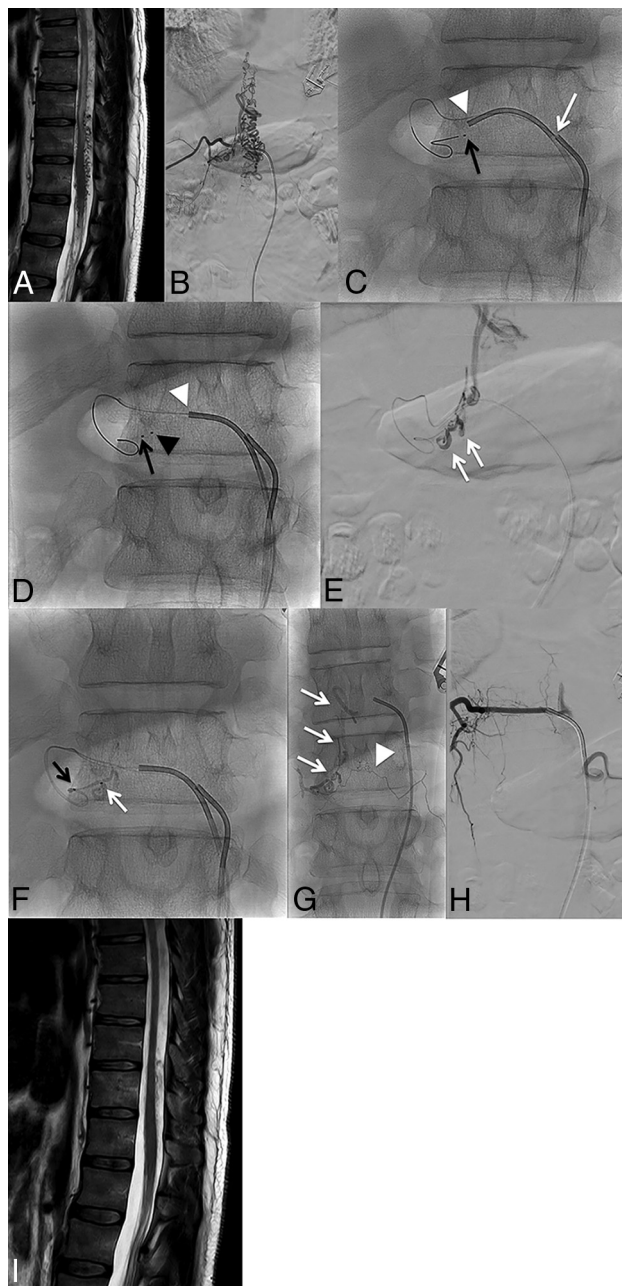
Patient in his or her 40's presenting with lower limb paresthesia, constipation, and bladder disturbance lasting for 36 months. *A*, Spinal cord MR imaging. T2WI, sagittal section, shows the hyperintense signal of the spinal cord extending up to T8 and multiple flow void signals in the enlarged spinal veins. *B*, Spinal DSA. Right T11 angiogram in a postero-anterior projection shows a spinal arteriovenous fistula with both ascending and descending venous drainage. *C*, Navigation of the microcatheter No. 1 (dedicated to the PCT plug) (black arrow). Then, the guiding catheter No. 1 is disengaged from the right T11 intercostal artery (white arrow). The guiding catheter No. 2 is subsequently positioned at the ostium of the segmental artery (white arrowhead). *D*, Navigation of the second microcatheter (No. 2) (black arrowhead) from the guiding catheter No. 2 (white arrowhead) as close as possible to the shunt point. Note the tip of microcatheter No. 1, located proximal to the tip of microcatheter No. 2. *E*, Ultraselective angiogram in a postero-anterior projection from microcatheter No. 2. The origin of the main draining vein (radicular vein) is clearly seen (double white arrow). *F*, PCT. Injection of 50% *n*-BCA through microcatheter No. 1 to create the proximal plug (black arrow). Then, injection of a 20% dilution of *n*-BCA is performed to embolize the fistula (white arrow). *G*, Plain x-ray in a postero-anterior projection shows the glue cast. Note the filling of the origin of the radicular vein (white arrows) and also progression of the liquid embolic agent through the retrocorporeal anastomosis (white arrowhead). *H*, Right T11 angiogram at the end of the procedure shows complete occlusion of the fistula. *I*, Spinal cord MR imaging 14 months after embolization. T2WI, sagittal section, shows complete resolution of the spinal cord edema.
